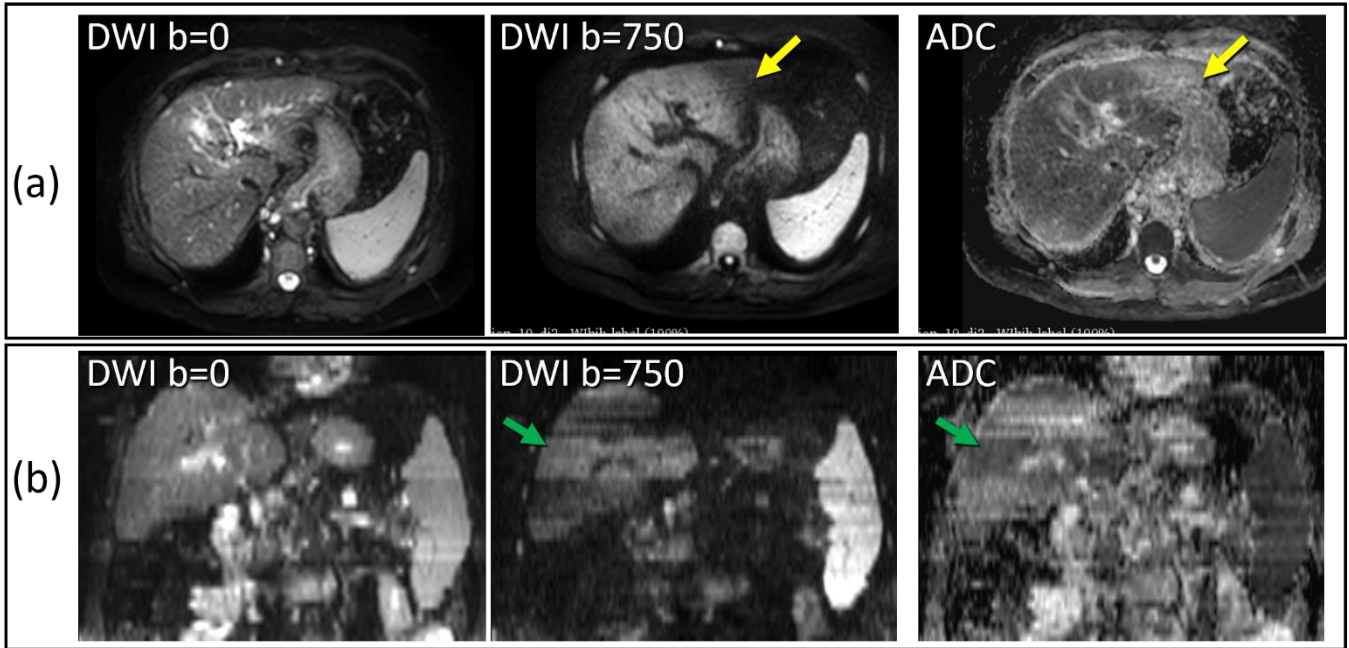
Visual assessment of motion artifact in liver DWI. (a) Areas of low signal on high  $b$ -value relative to adjacent tissue may result from motion. Cardiac pulsation transmitted to left lobe artifactually inflates ADC (yellow arrows). (b) Reformat of axial DWI/ADC to coronal can aid identification of motion artifact seen as bands on high  $b$ -value and ADC (green arrows).
